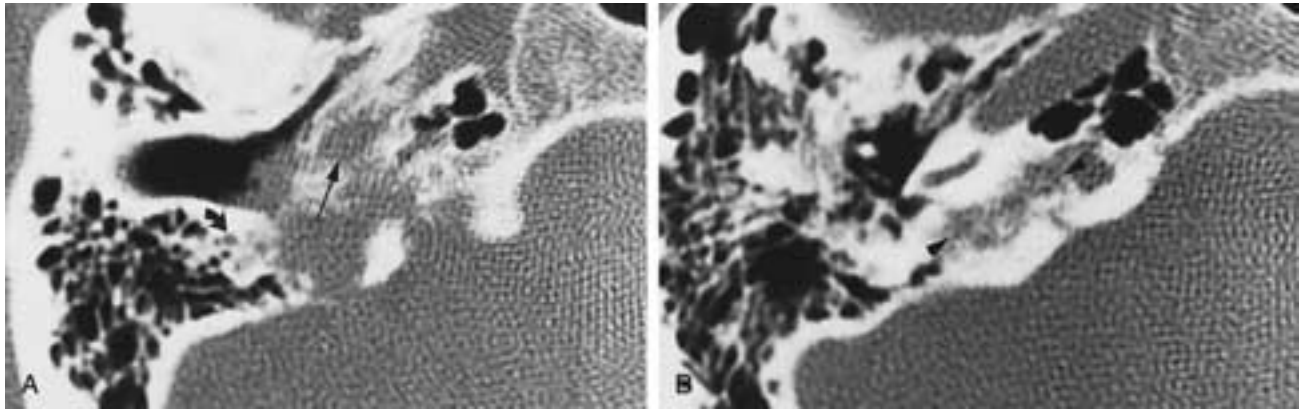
Medium-sized glomus jugulare tumor. A and B, Axial CT. Fisch type C2 tumor destroying the fossa-infiltrating vertical carotid canal (*arrow*) and infralabyrinthine compartment (*arrowheads*), bypassing the dense bone of the otic capsule. The tumor is resectable by the infratemporal fossa approach, with anterior rerouting of the facial nerve (*curved arrow*).
